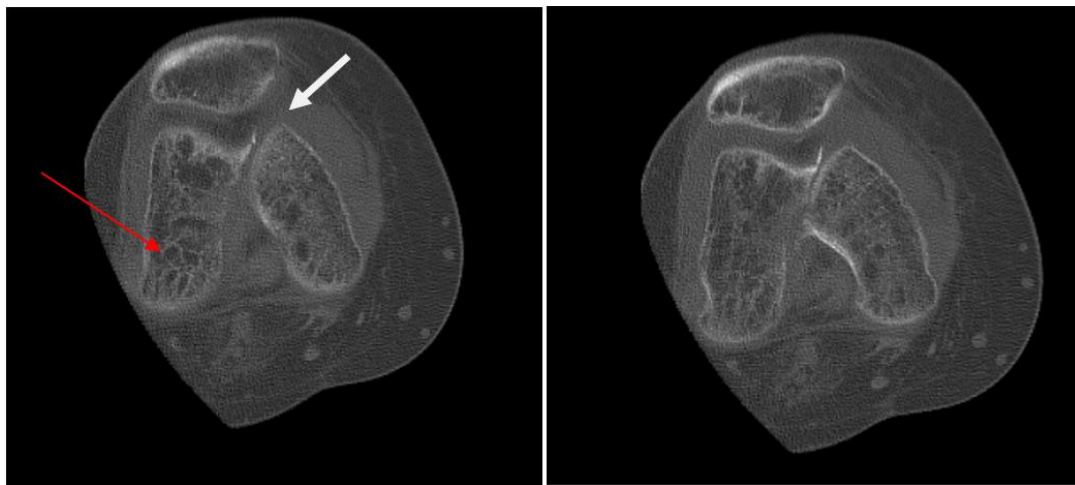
Non-contrast CT scan of the right knee showing a partial articular fracture of the medial femoral condyle (white arrow) on demineralized bone. Multiple subchondral cysts (red arrows) suggestive of type I complex regional pain syndrome
